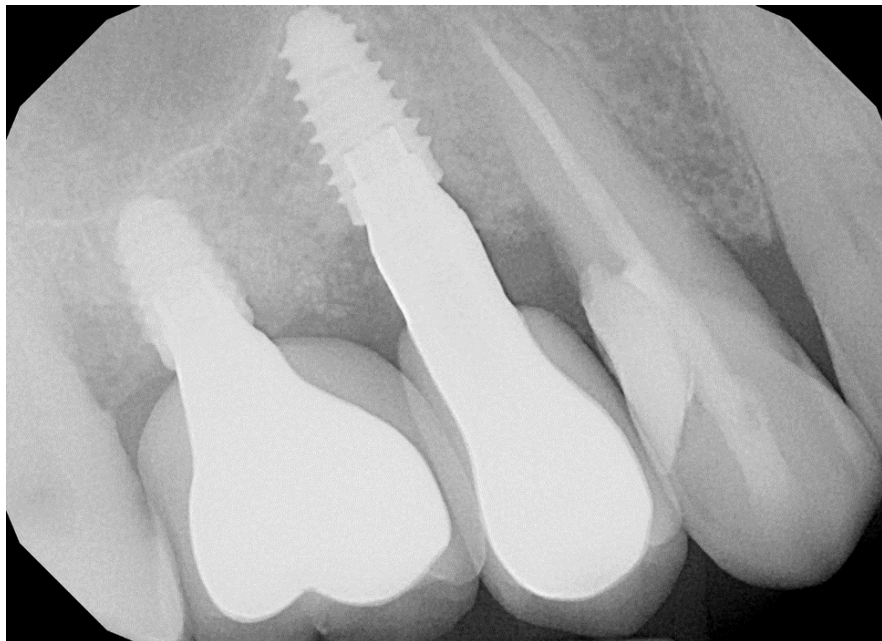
Radiographic image after removal of tooth #3 and of implant #4 and replacement with 2 Megagen implants.
